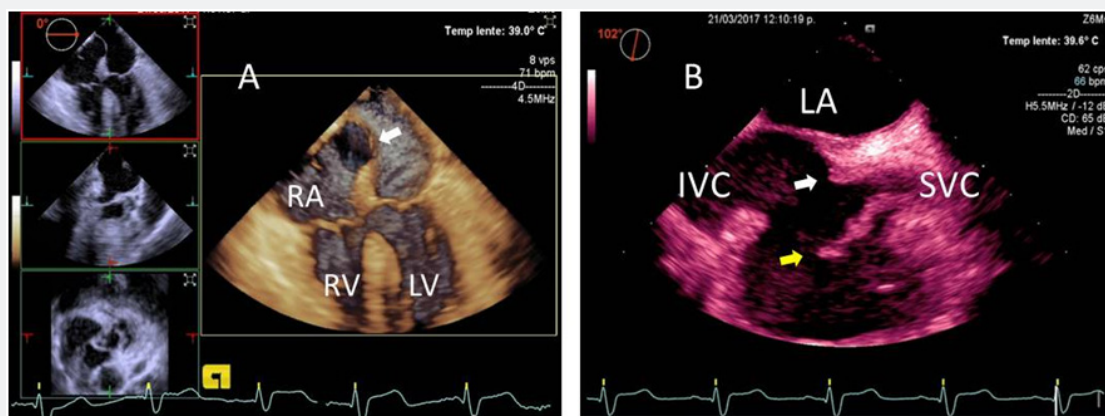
Transesophageal study: A) Three-dimensional transesophageal four chamber view at 0° showing aneurysm of the interatrial septum (white arrow), without any vegetation in the auriculoventricular valves. RA: Right Atrium; LV: Left Ventricle; RV: Right Ventricle. B) Transesophageal two dimensional image at 102° showing a large vegetation attached in the superior vena cava (yellow arrow) and also an thickness in the interatrial septum suggesting an abscess (white arrow).
